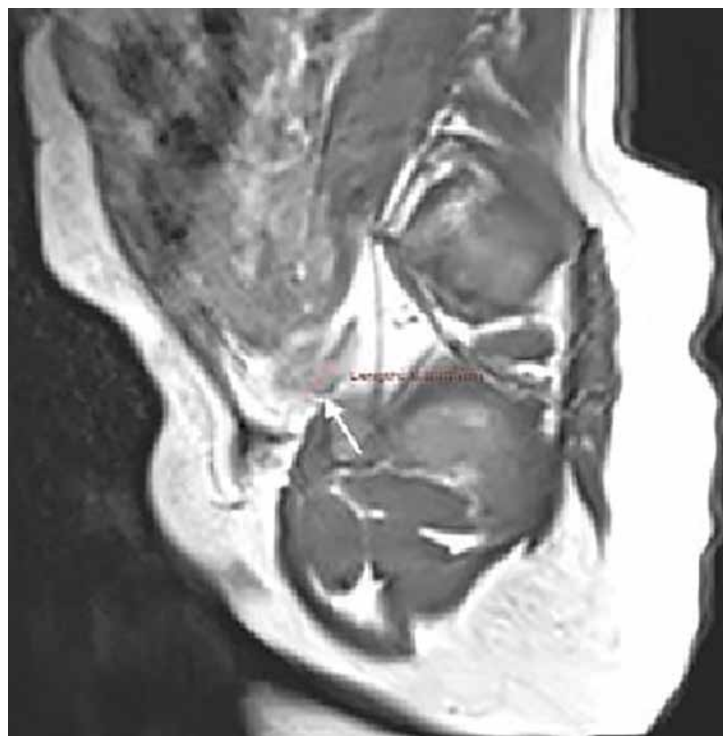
MRI of the pelvis demonstrating the presence of the left testis in the pelvis, near the left inguinal canal.
